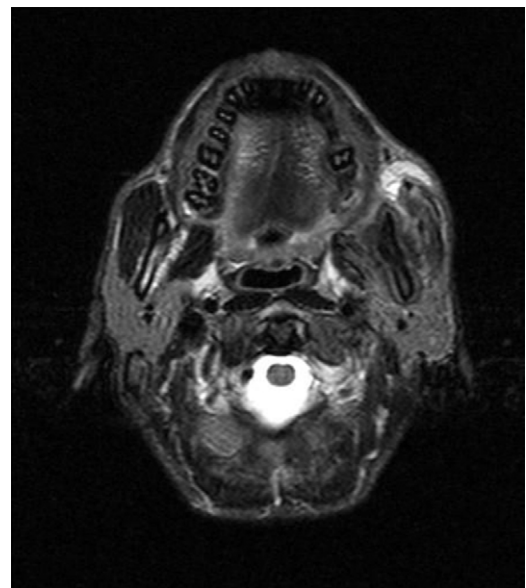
MRI, axial section, showing focal areas of necrotic patches.
